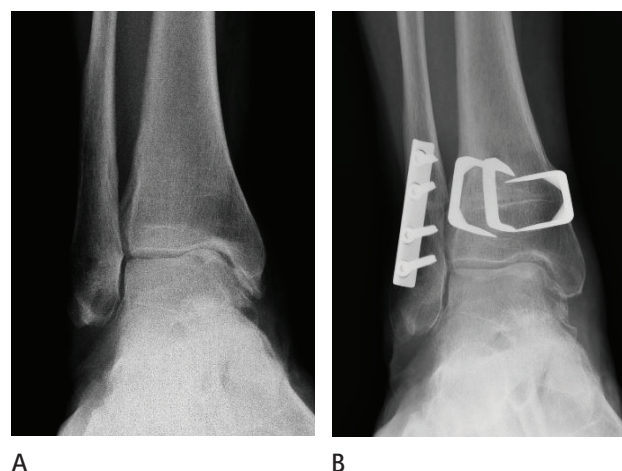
AP views of weight bearing x-rays of the right ankle of a 60 year old woman before (A) and two years after (B) supramalleolar lateral closing wedge osteotomy and deltoid ligament release for early stage varus ankle osteoarthritis associated with intra articular deformity. Note that, due to the lateral shift of the weight bearing axis, the narrowing of the medial joint space has been addressed successfully.
